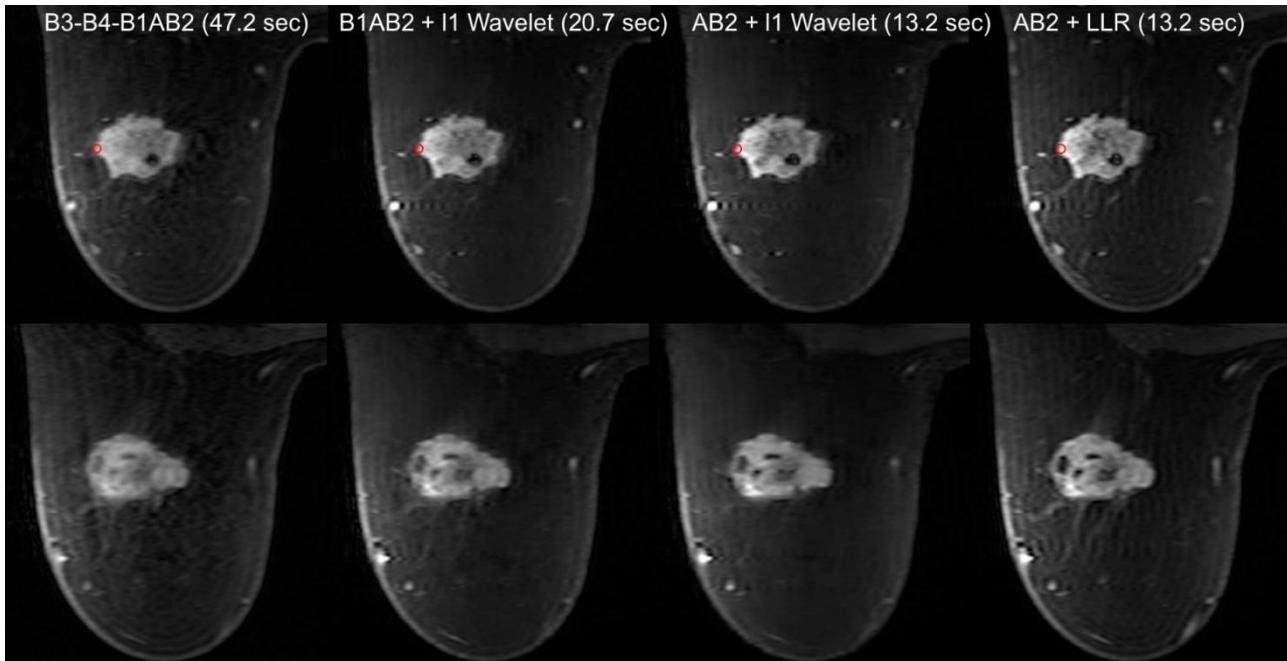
Two slices from breast DCE-MRI images reconstructed with view-sharing, f1-wavelet regularization in the spatial domain, and locally low rank regularization at variable temporal footprints are shown. (DISCO uses a notation where “A” is the central k-space, while the “B_i” represent subsampled outer k-space regions, so “AB1” is more heavily subsampled than “B1AB2” and has a higher effective frame rate. Locally low rank-regularized reconstructions exploiting spatial and temporal redundancy show the sharpest delineation of lesion boundaries.
